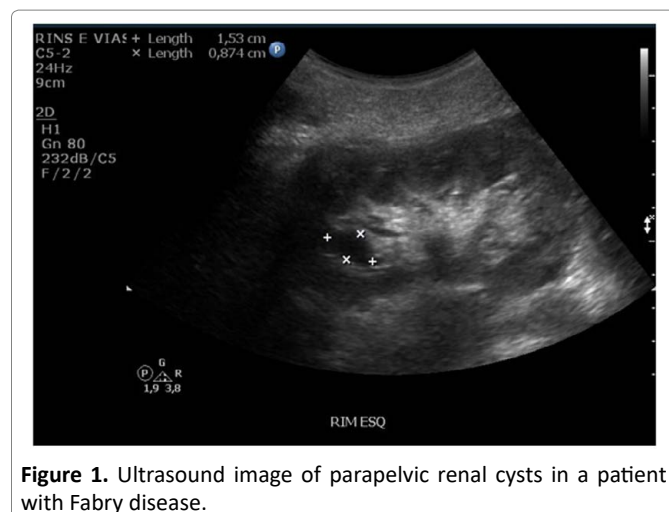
Ultrasound image of parapelvic renal cysts in a patient with Fabry disease.
